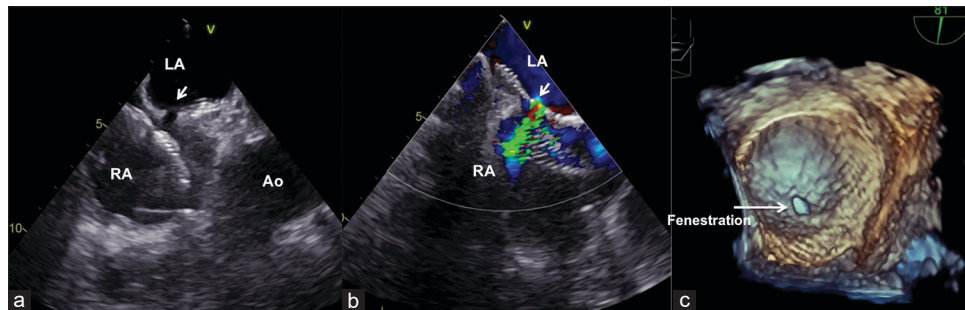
Transesophageal echocardiogram after 4 years (a) showed the fenestration (arrow), with color flows (b) from the LA to the RA. Three-dimensional echocardiogram (c) showed the fenestration in the left atrial enface view. LA: Left atrium, RA: Right atrium
